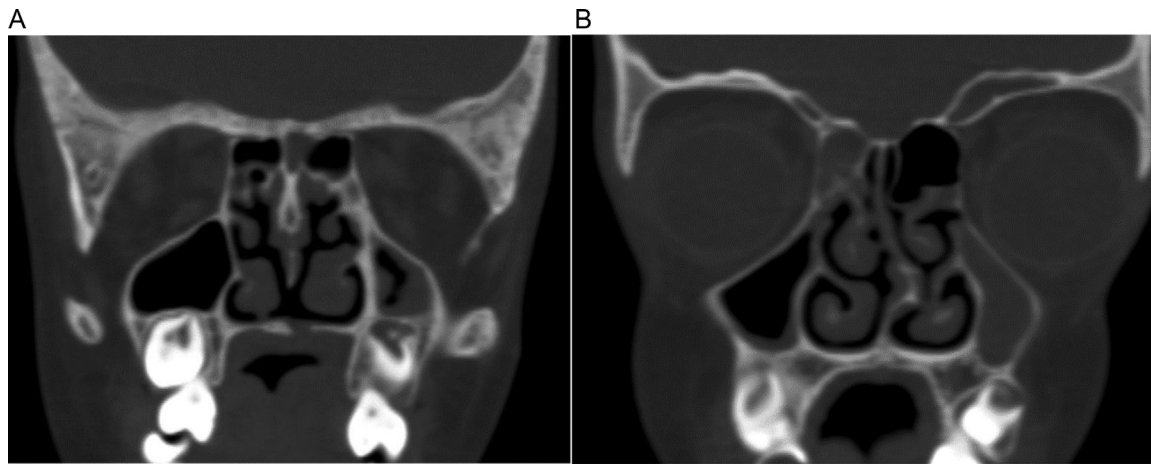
(A and B) Coronal CT images showing a small cleft palate in the posterior hard palate. There is left-sided deviation of the nasal septum with a bony spur. Bilateral paranasal sinuses appear normal.
